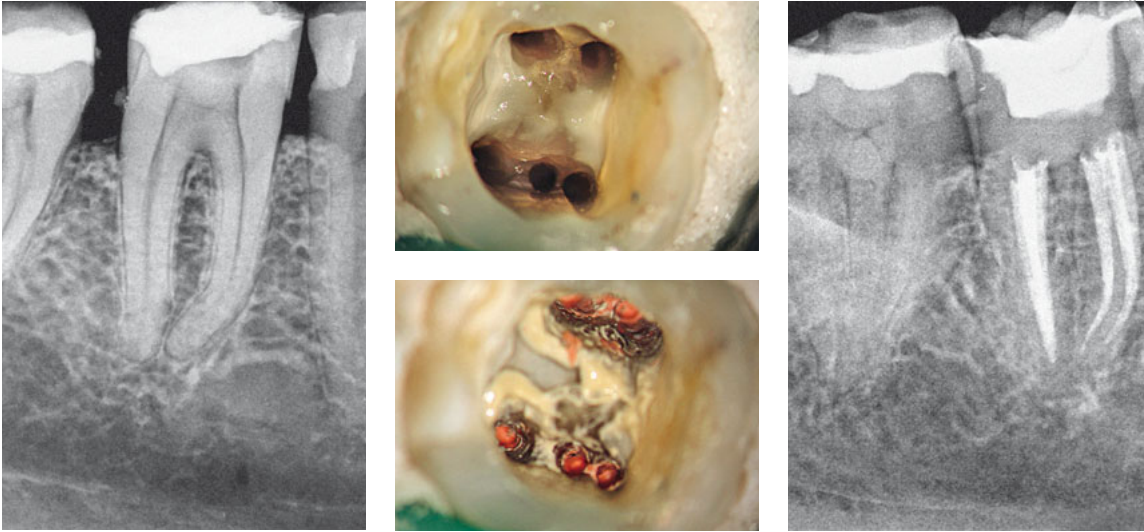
The diagnostic radiograph shows accessible root canals in both roots, but does not provide information regarding the number of canals. After the preparation of an adequate access cavity, the root canal orifices were found and the canals were shaped and sealed.
